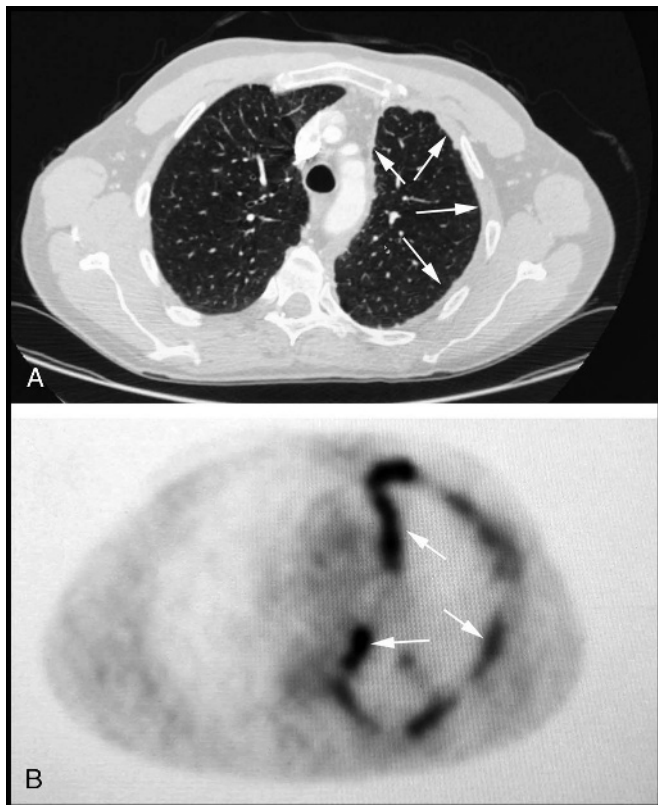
Axial contrast-enhanced computed tomography scan (A) showed circumferential left-sided pleural thickening (arrows). Positron emission tomography scan (B) showed diffusely increased fluoro-deoxy-glucose uptake in the pleura of the left hemithorax (arrows) without other abnormalities.
